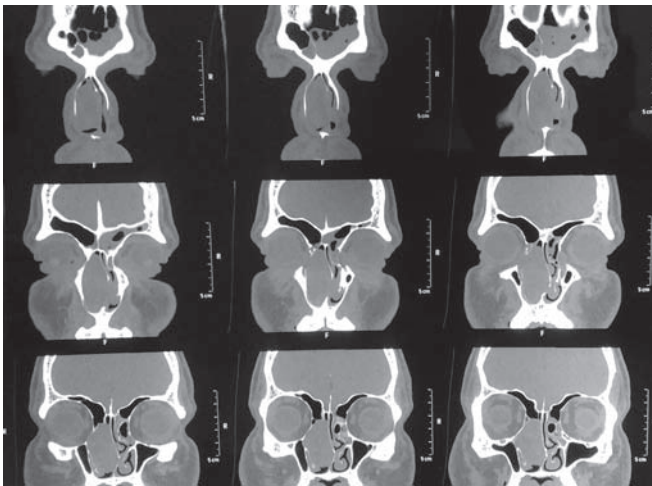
Computed tomography scan (coronal cuts) reveal polypoidal soft tissue mass measuring $5.4 \times 1.9 \times 3.8$ cm in the right nasal cavity. Right middle turbinate was not defined and rarefaction of inferior concha and obliteration of osteomeatal complex was seen
